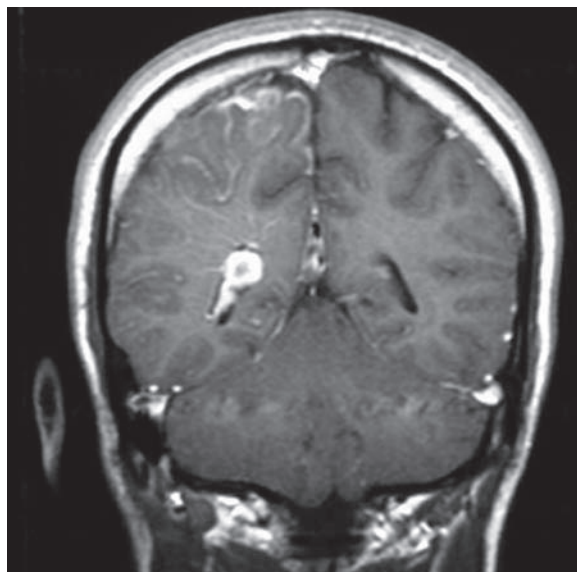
Sturge-Weber syndrome. Post-contrast MRI shows the characteristic features of Sturge-Weber syndrome with abnormal enhancement, suggesting calcification in the cortical veins, together with right hemisphere atrophy
